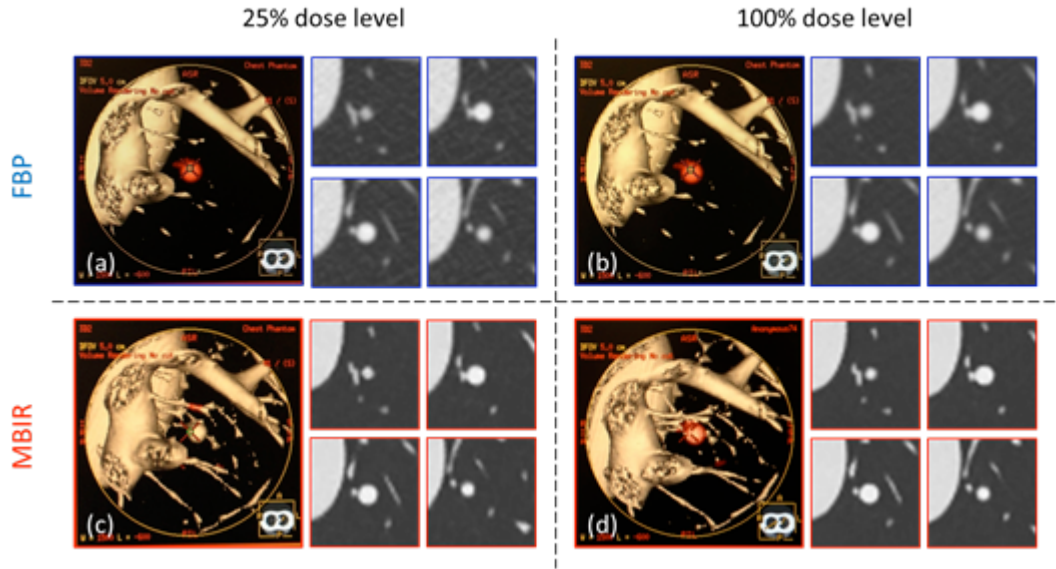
Three dimensional surface rendering and CT slices of the 4.76 mm nodule that (a,b) succeeded in the segmentation with FBP but (c,d) failed in the segmentation with MBIR.
